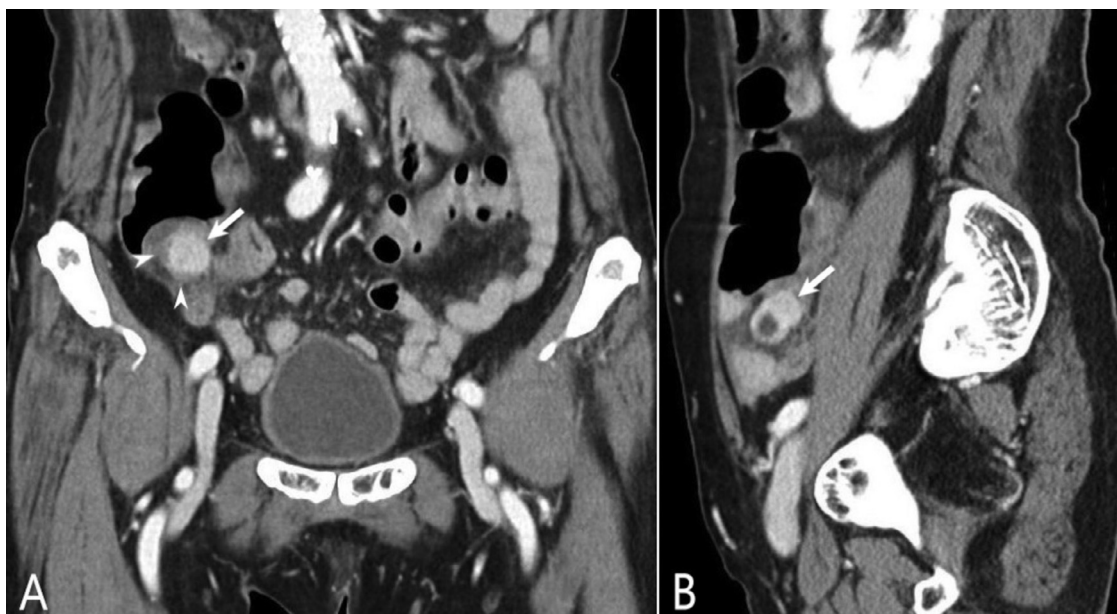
Contrast-enhanced coronal and sagittal computed tomography scans. (A, B) The mass is located in submucosal layer, and has normal overlying mucosa (A, arrow heads).
